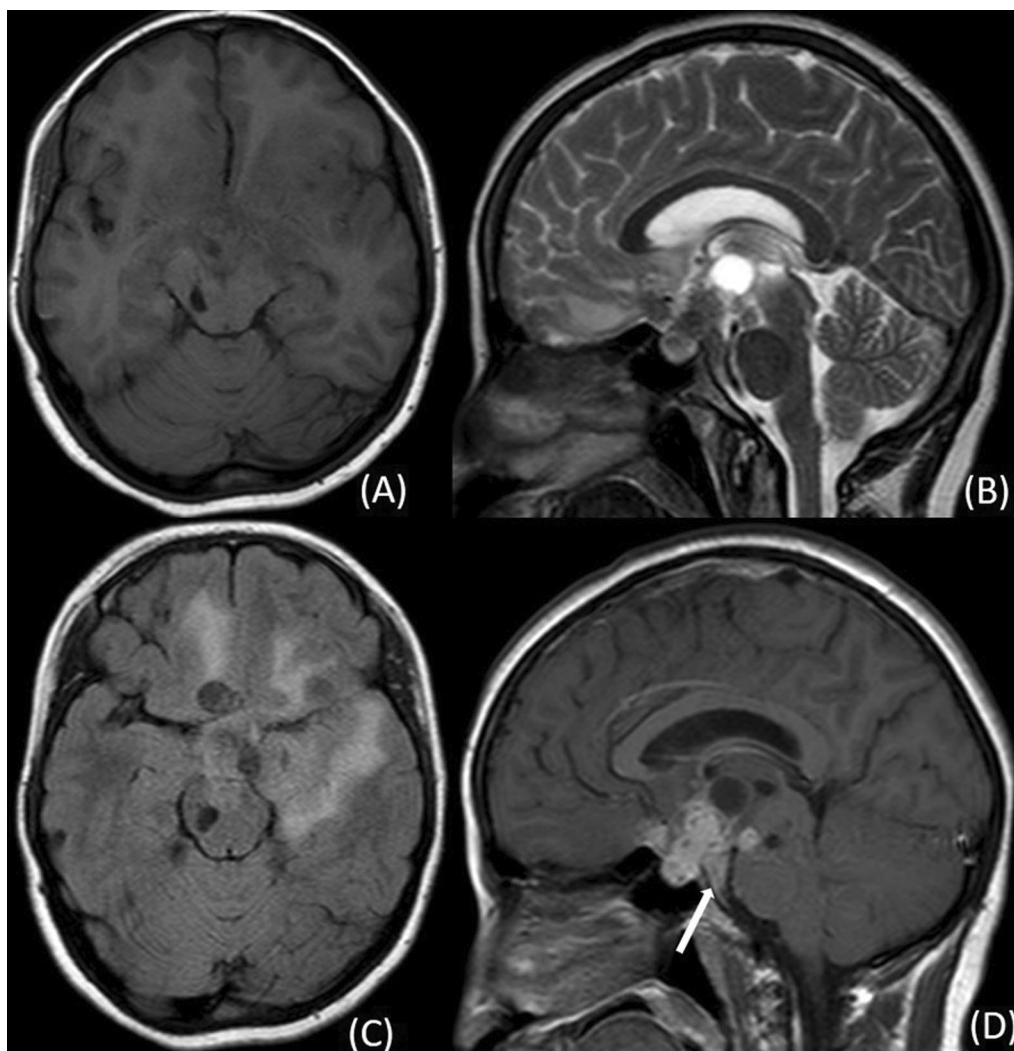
Pituitary and hypothalamic tubercular granulomas. MRI of a 24-year-old male shows multiple conglomerate lesions in pituitary, hypothalamus and midbrain which appear isointense with hyperintense rim on axial T1W image (A), variable signal intensity on T2W image (B), extensive surrounding white matter oedema is seen on FLAIR (C), on T1 contrast-enhanced image the lesions show peripheral enhancement with basal exudates in preoptine cistern (arrow in D)
